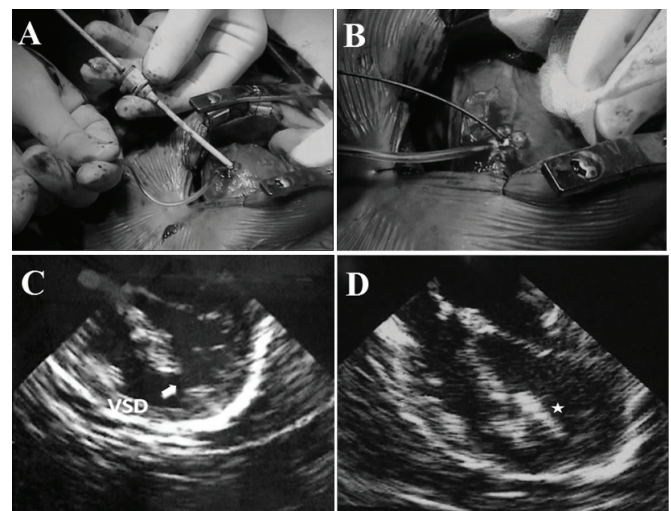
Intraoperative ventricular septal defect device closure (A, B) and echocardiography prior to (C) and following implantation (D).
